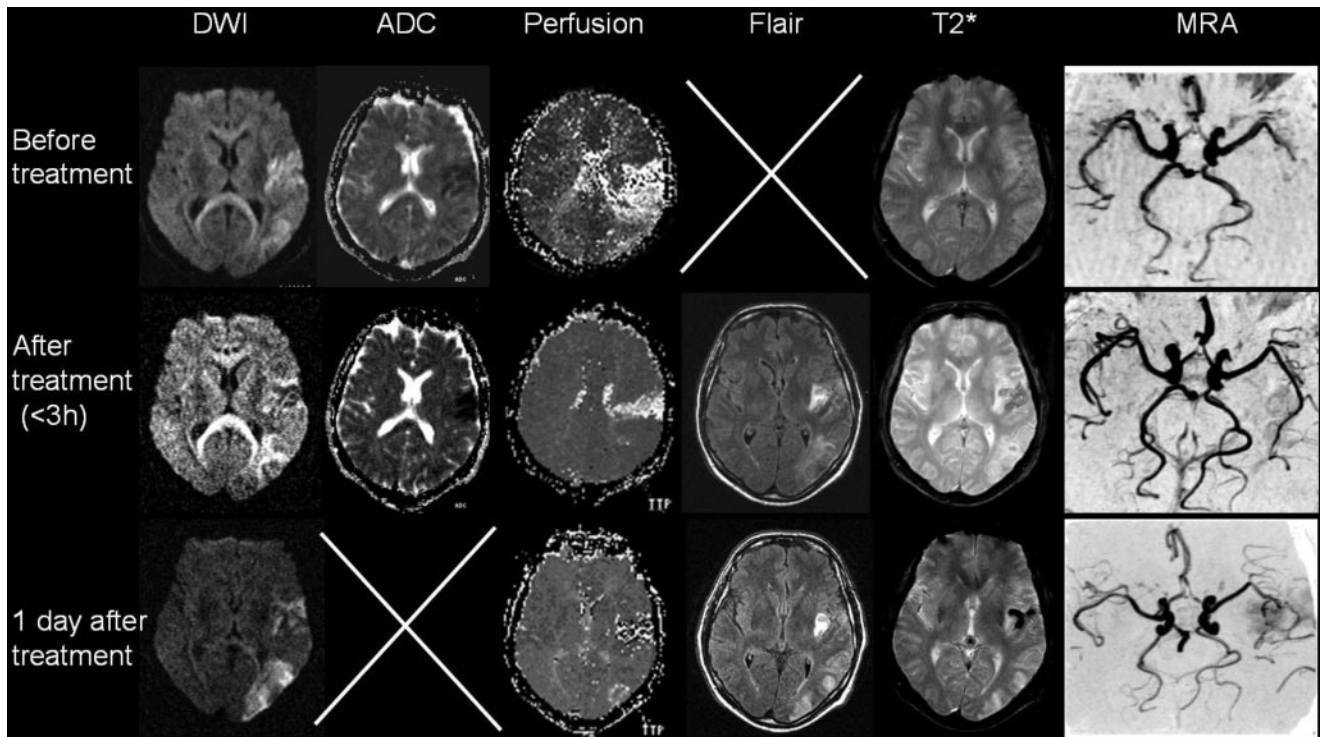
A 67-year-old patient with an acute right-side hemiparesis and aphasia (NIH 15). Treatment (tPA plus ultrasound) started 180 minutes after symptom onset. Pretreatment MRI (upper row) showed left hemispheric hypoperfusion extending the DWI/ADC deficit. MRA revealed occlusion within the M2 segment of the middle cerebral artery. Posttreatment MRI (middle row) displayed a decreasing territory of perfusion, but ADC abnormalities were almost unchanged. MRA showed reopening of the main M2 segment area, and some minor branches still seem to be occluded. Posttreatment NIH score was 8. Follow-up MRI 24 hours after symptom onset (lower row) showed residual infarction in DWI and FLAIR sequences. T2* imaging showed some subtle hemorrhagic transformation. At 3-month follow-up, NIH was 2, Barthel was 95, and Rankin was 1.
